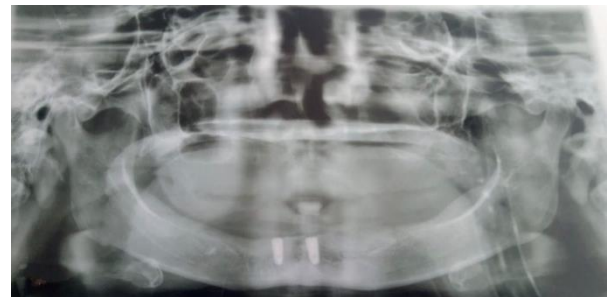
Panoramic radiograph showing implant parallelism.
